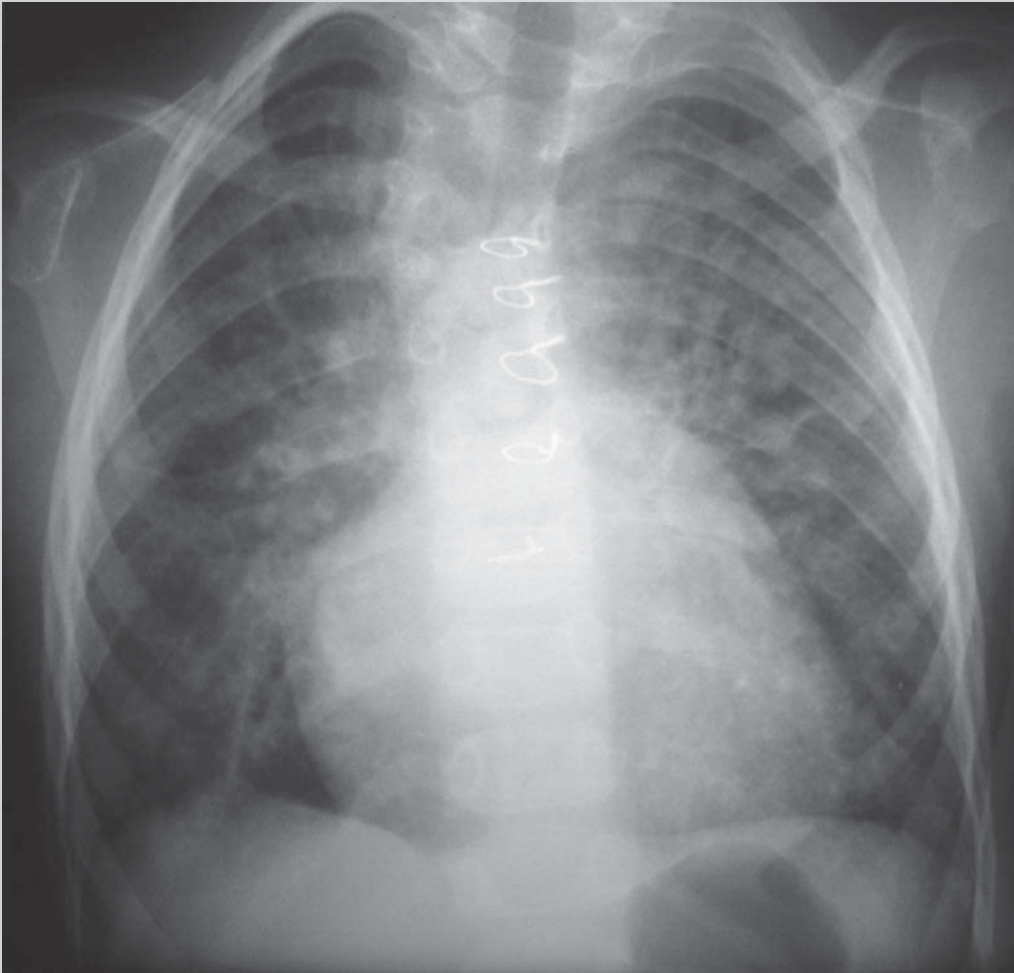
Chest radiograph shows a cardiac shape similar to that found in the tetralogy of Fallot. However, the increased pulmonary vasculature suggests pulmonary atresia with ventricular septal defect and large-diameter systemic-to-pulmonary collateral vessels
